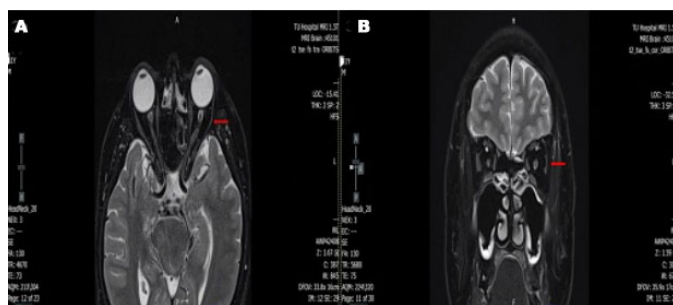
MRI orbit (A) axial view and (B) coronal view show atrophic change of left lateral rectus muscle (red arrow).
